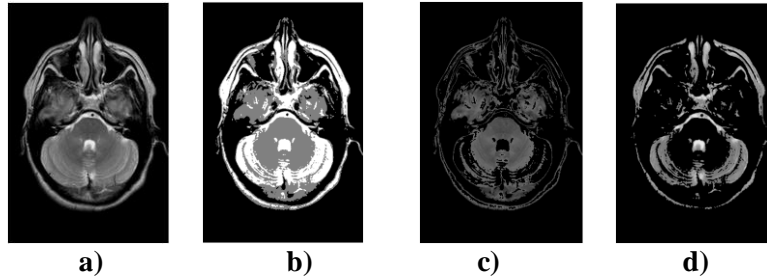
10 k-means algorithm applied on MRI slice (2 classes in this case)
